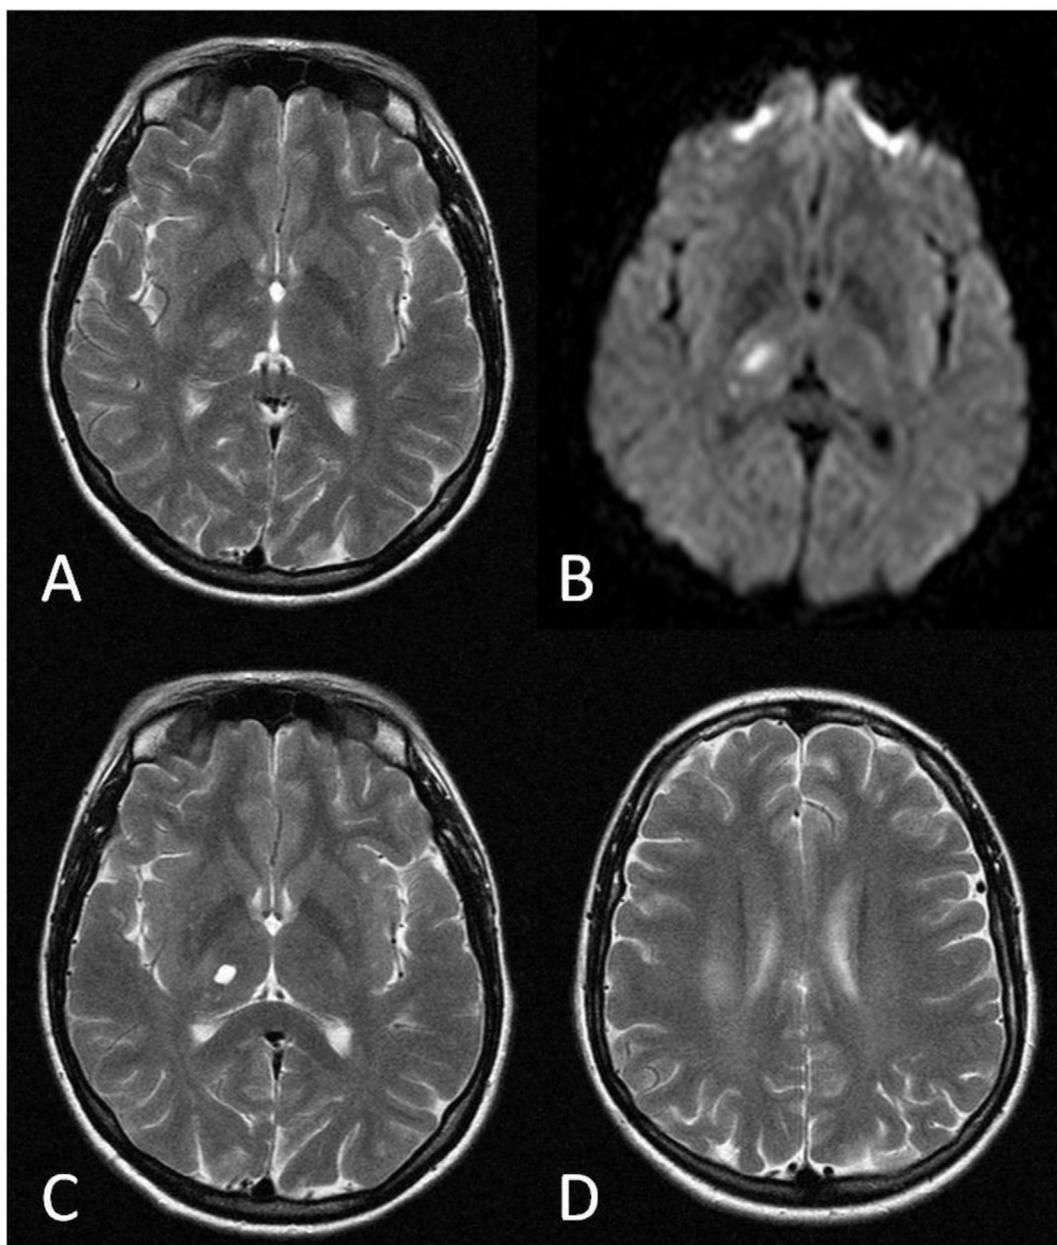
A, B) Brain MRI acquired five hours after the onset of symptoms. Axial T2-weighted image (A) shows a thalamic hyperintense lesion on the right side; axial diffusion-weighted image shows that the lesion is characterized by restricted proton diffusivity. (C and D) Follow-up brain MRI performed after six months. Axial T2-weighted image (C) shows malacic evolution of the lesion with signs of anterograde degeneration along homolateral centrum semiovale white matter fibers (D).
